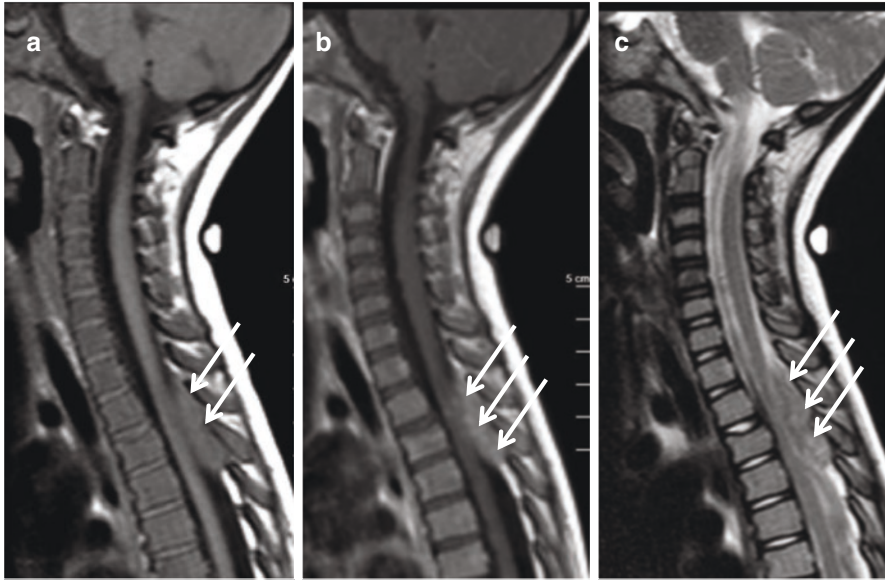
Sagittal spine MRI of metastatic neuroblastoma in a 3-year-old child. The metastasis are highlighted by white bold arrows. The tumor at levels T1–T3, caused compression of spinal cord. The patient had upper extremity sensory changes and was also found to have a palpable abdominal mass. (a) T1-weighted sequence, (b) Postcontrast T1-weighted, (c) T2-weighted
